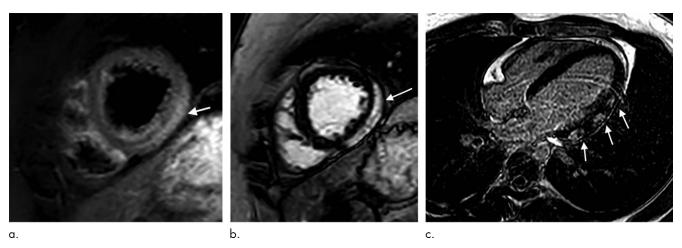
Images in a 22-year-old man with COVID-19, shortness of breath, and chest pain. Cardiac MRI demonstrates mildly reduced left ventricular systolic function with ejection fraction of 47%. (a) T2 short-axis image through apical segments demonstrates subepicardial edema (high signal, arrow) along lateral wall. (b, c) There is corresponding subepicardial lateral wall late gadolinium enhancement on short-axis (arrow in b) and four-chamber (arrows in c) images.
